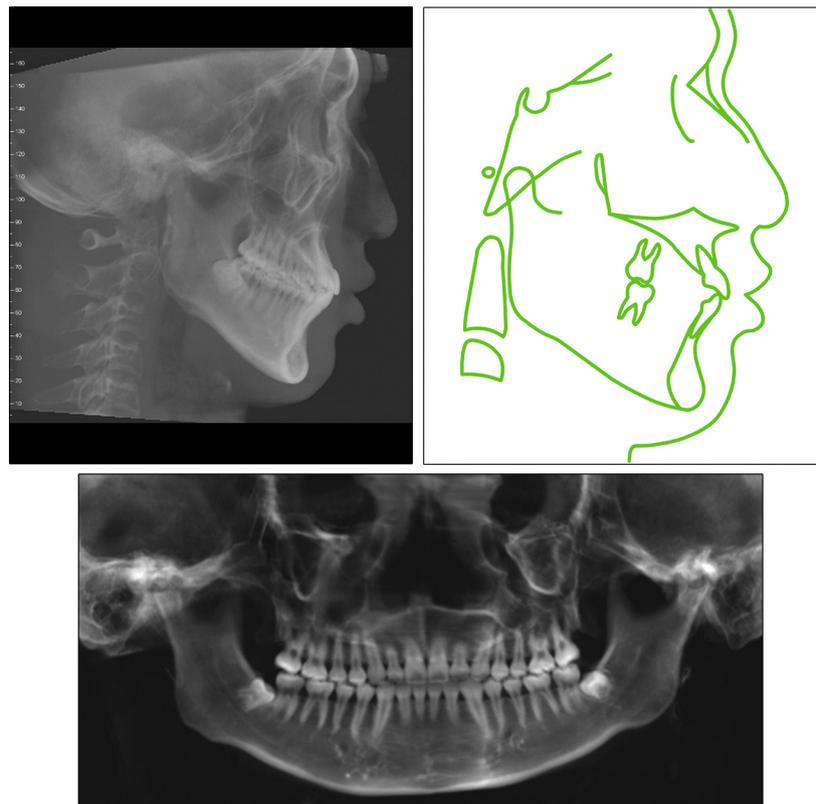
Four-year postretention lateral cephalogram and tracing and panoramic radiograph.
